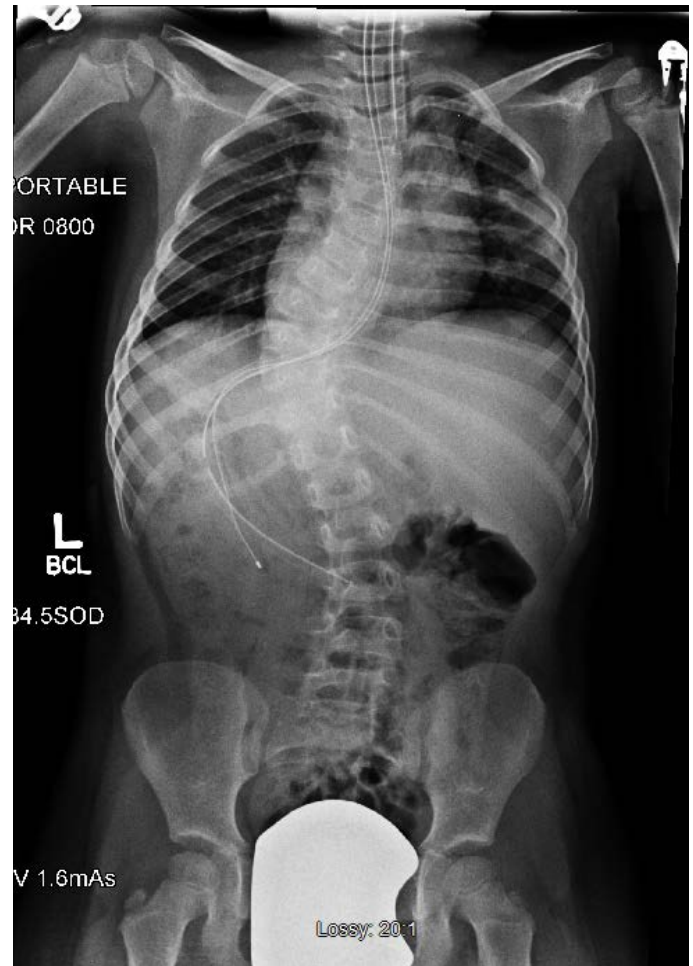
Pre-casting radiograph on the same patient obtained without a grid. The endplates are less well defined but still discernable.
